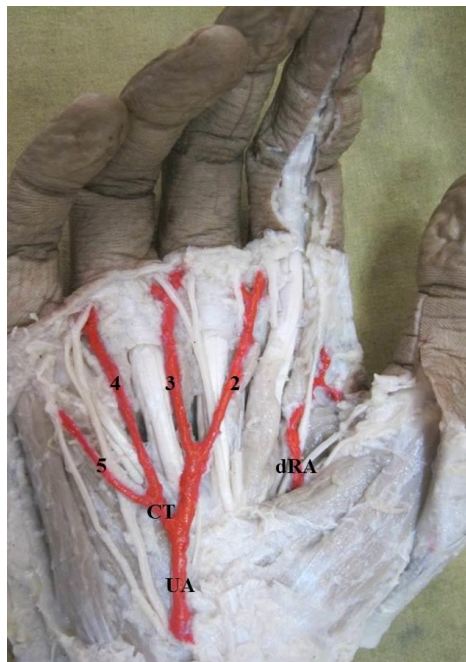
Right hand showing an Incomplete SVA(ulnar type, with ulnar artery supplying the medial three and a half digits and rest by the deep branch of radial artery).UA – Superficial branch of ulnar artery; dRA – Deep branch of radial artery; 2, 3, 4 – 2nd, 3rd and 4th common digital arteries; 5 – Proper digital artery; CT – common trunk for 4th common digital artery and proper digital artery for the little finger.
